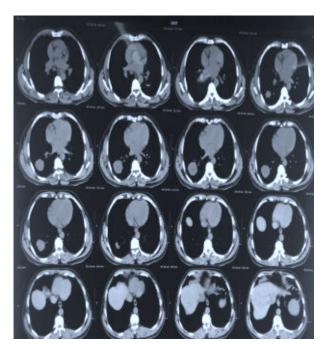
CT Scan Mediastinal view
